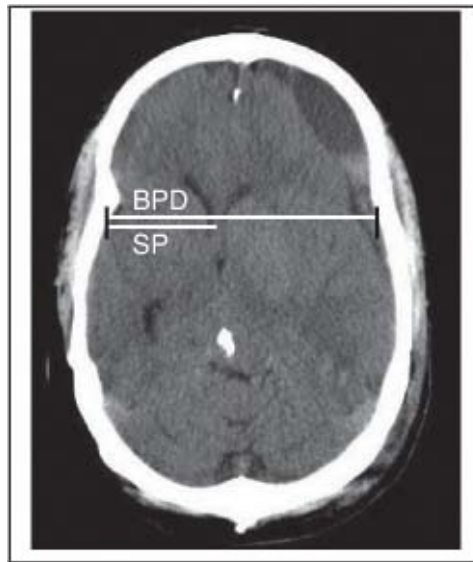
Measurement of midline shift (CT of a patient with subdural hematoma)
